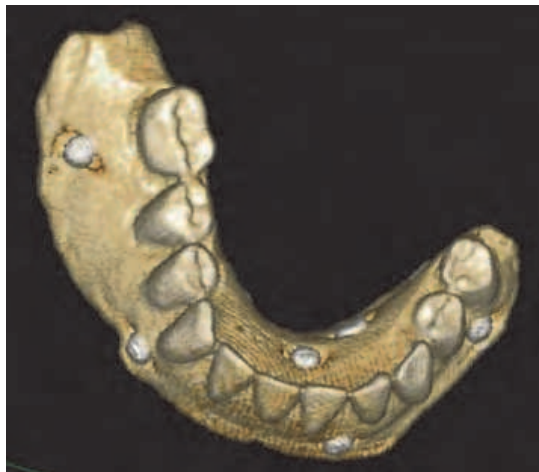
Three dimensional CT scan reconstruction of temporary prosthesis with gutta percha balls.
